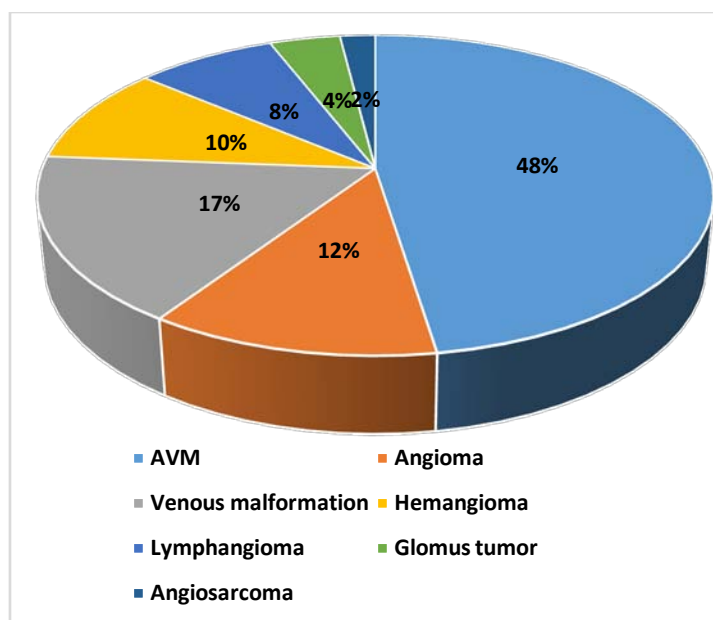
Ultrasound Data Combined with CT Angiography
